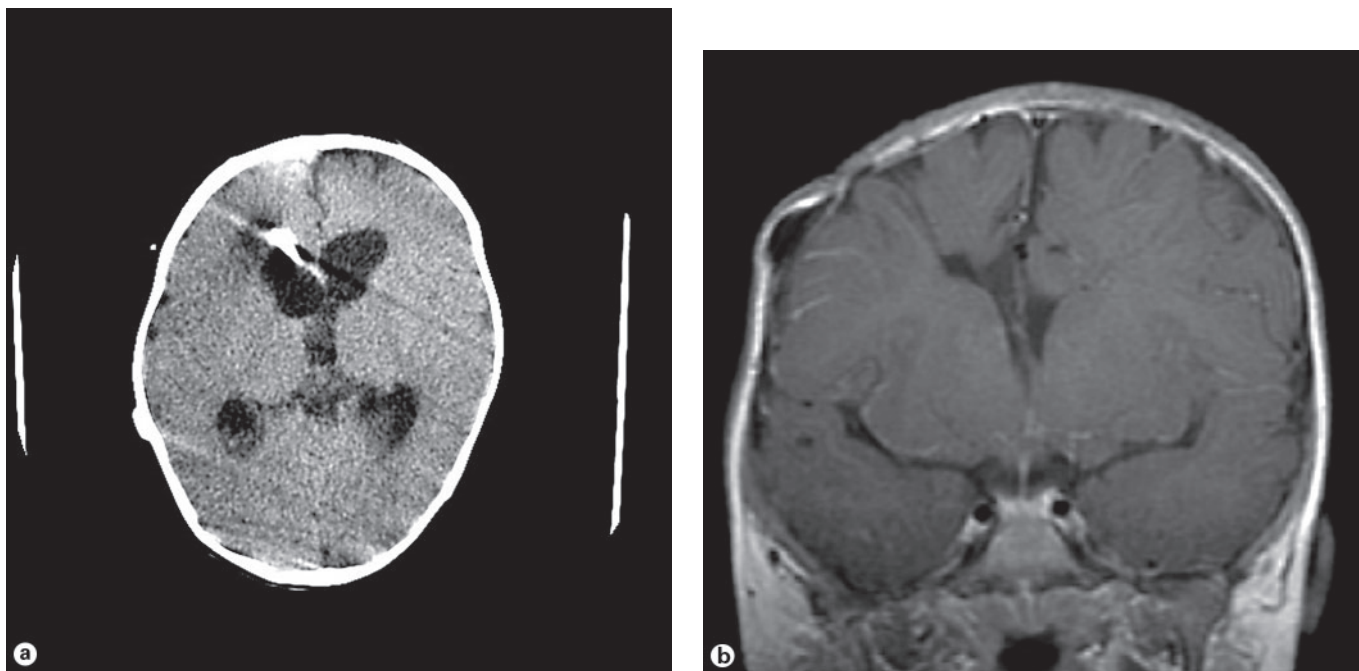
a Postcontrast CT scan immediately following the second surgery, showing no visible residual tumor. At surgery, a tiny amount of residual tumor was left because it was densely adherent to the internal cerebral veins. b Follow-up postcontrast MRI 4 years following surgery and an intensive chemotherapy regimen, demonstrating no recurrent tumor.
